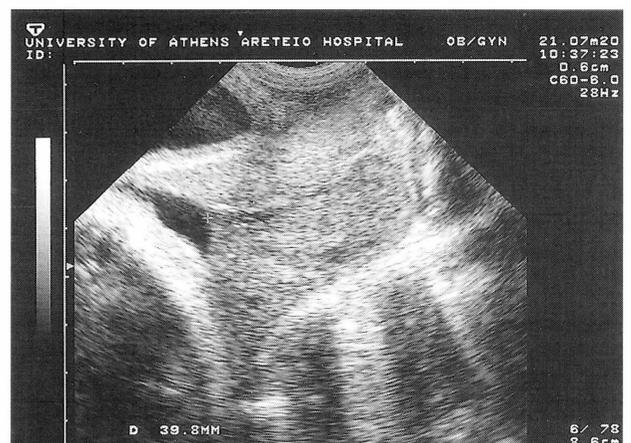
Pregnancy with normal cervix by transvaginal ultrasound (30th week).
